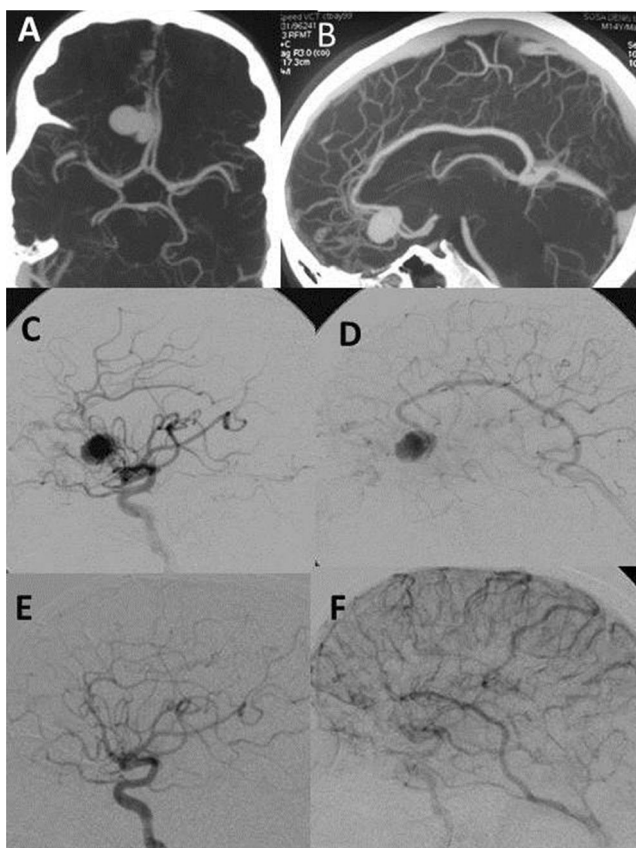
Case no. 2. a, b CT angiography. Axial and lateral views. A dilated vein (varix) in the midline of the frontal lobe is seen. The pericallosal artery feeds the PAVF, and the varix drains in a dilated pericallosal vein. c Anteroposterior and d lateral projection of a DSA depicting the PAVF, the varix, and the pericallosal vein. It was decided to remove the varix which is responsible for the seizures by microsurgery. d, e Postoperative DSA
